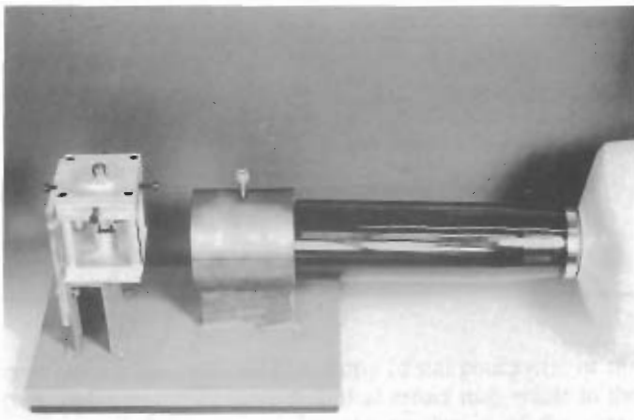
Correct positioning of the radiographic device.
